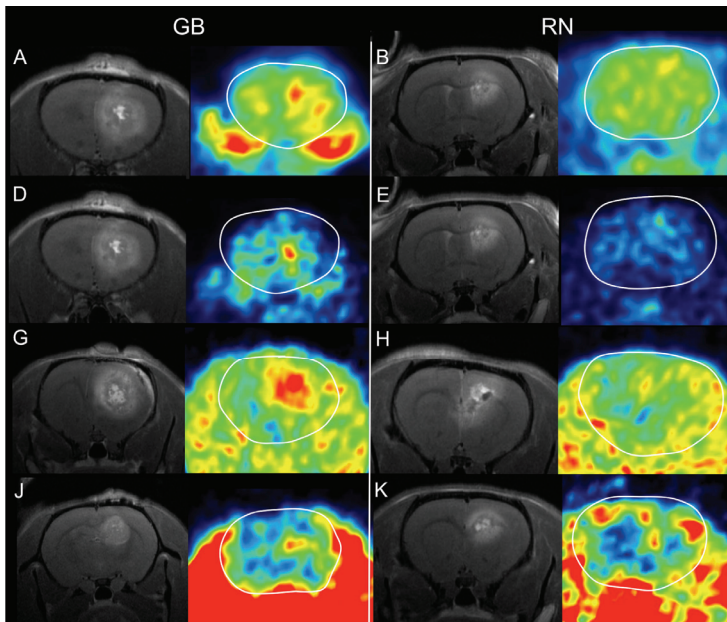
Contrast-enhanced MRI and PET of GB and RN. For clarity, the brain is contoured in white. ^{18}F -FDG PET 40 min post-injection (A-B) and 240 min post-injection (D-E). ^{18}F -FET PET 35 min post-injection (G-H) and ^{18}F -FCho PET 10 min post-injection (J-K).
